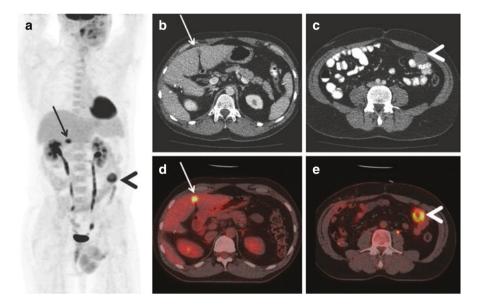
Peritoneal metastases from colorectal primary. 47-year-old male with colonic cancer previously treated with right hemicolectomy and liver resection presented 1 year later with suspected solitary peritoneal metastases on CT. Axial CT demonstrated the left anterior flank deposit (arrow in c) however a subtle low attenuation deposit in the falciform ligament (arrow in b) was not picked up however is clearly seen as an intensely FDG avid focus on the fused PET-CT image (arrow in d). MIP image (a) clearly shows both the deposits. PET-CT has superior accuracy than conventional CT in detecting peritoneal metastases
